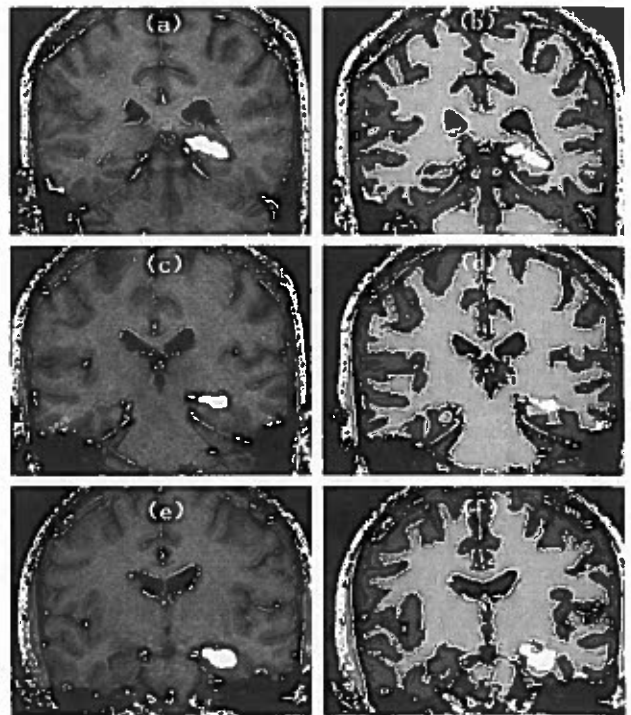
(a) Slice 2 of 13 from MRI series, with manual hippocampal identification. (b) Segmentation of (a), with automatic hippocampal identification. (c) and (d); slice 6 of 13. (e) and (f); slice 10 of 13.
